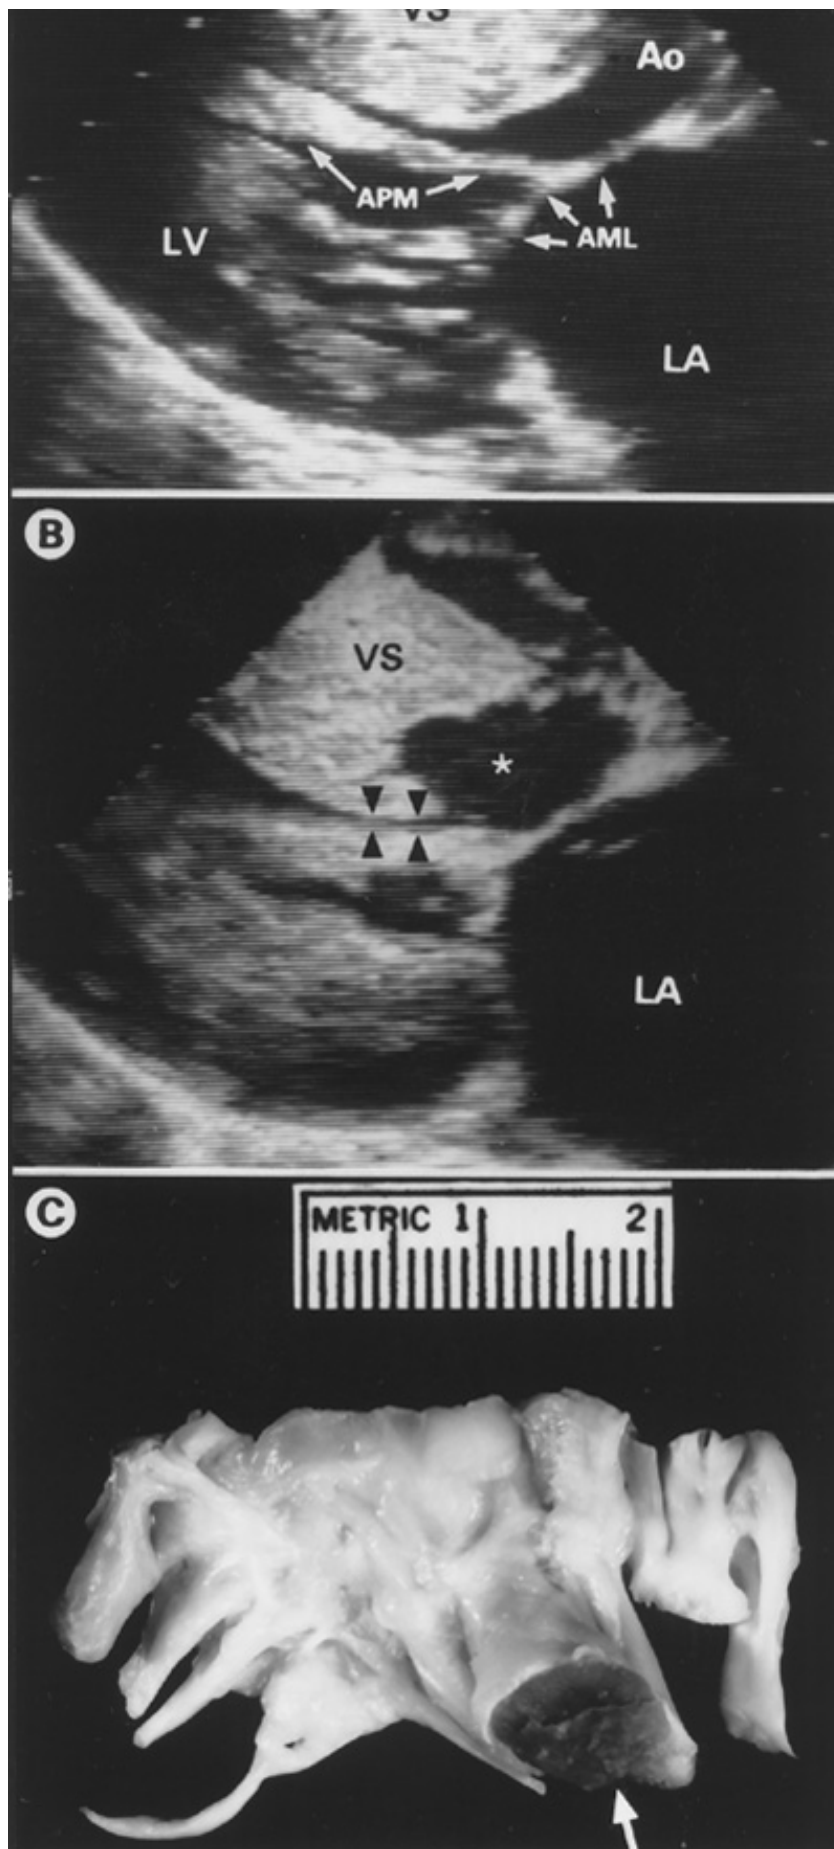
Anomalous papillary muscle insertion directly into anterior mitral leaflet (AML) in patient with obstructive HCM. A. *Before myotomy-myectomy*: parasternal long-axis
